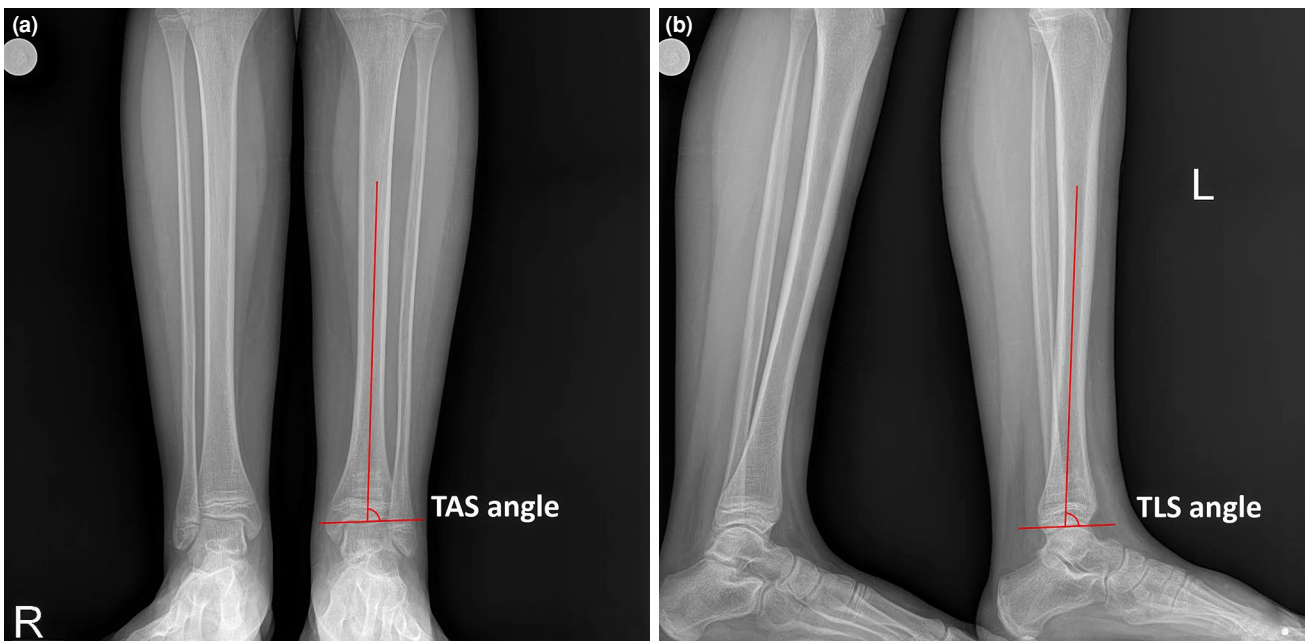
(a) The tibial anterior surface (TAS) angle is defined as the angle between the tibial axis and the distal tibial articular surface on the weight-bearing anteroposterior radiograph. (b) The tibial lateral surface (TLS) angle is defined as the angle between the tibial axis and the distal tibial articular surface on the weight-bearing lateral radiograph.
